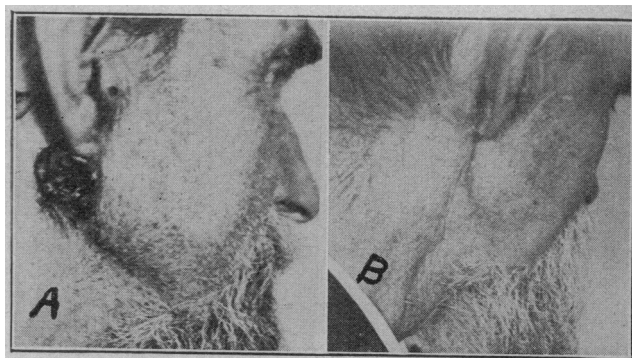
A, basal cell epithelioma, involving tissue and bone at angle of jaw, in a man, aged 73, referred by Dr. John Hedges of Philadelphia. The roentgen ray had previously been used without success. One desiccation treatment under local anesthesia was given in March, 1917. B, result of one treatment. Note absence of contracted scar. No recurrence in one year and a half.
